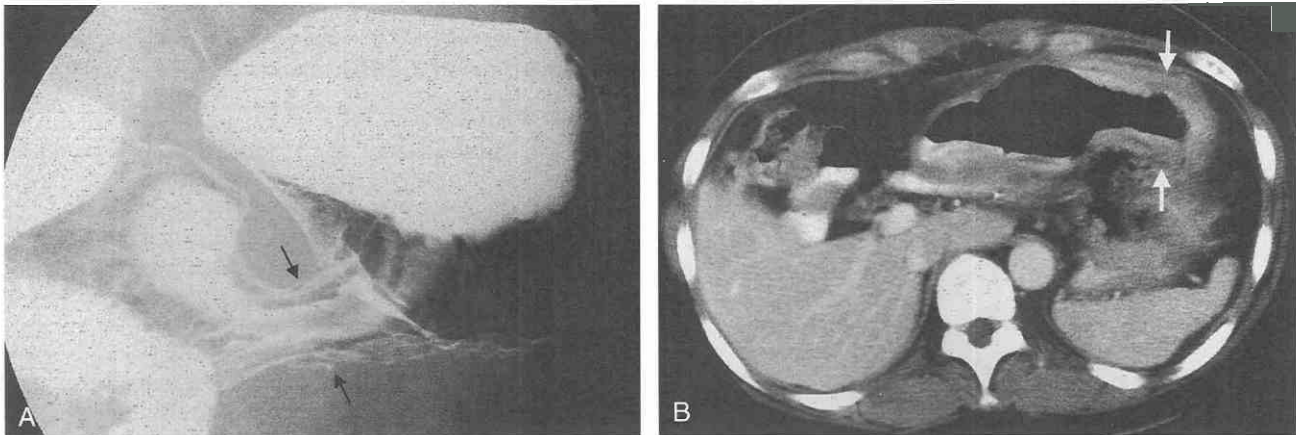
Metastasis to the stomach (linitis plastica) from breast cancer. *A*, Double-contrast upper gastrointestinal series shows focal luminal narrowing (arrows), rigidity, and fold thickening in the proximal antrum and lower body of the stomach. *B*, CT scan shows involvement of the stomach by a scirrhous tumor.
